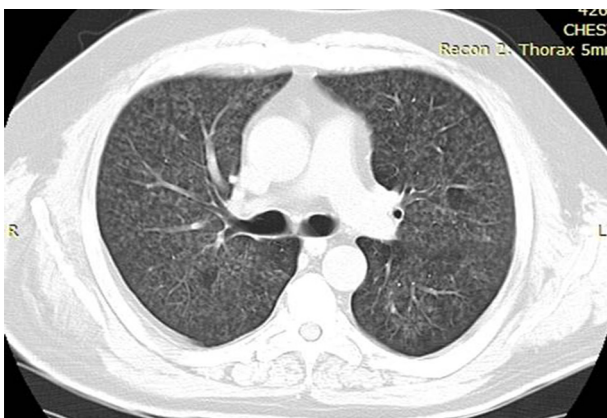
Chest high-resolution computed tomography. Diffuse low attenuation micronodular pattern.
